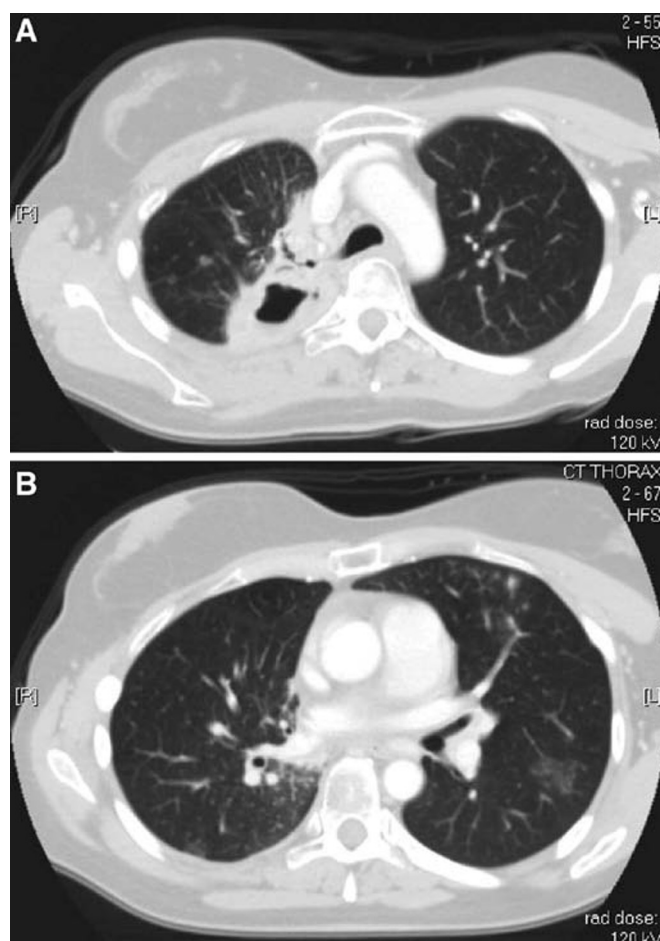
Computed tomography scan at time of presentation showing cavitation and multiple lesions.
